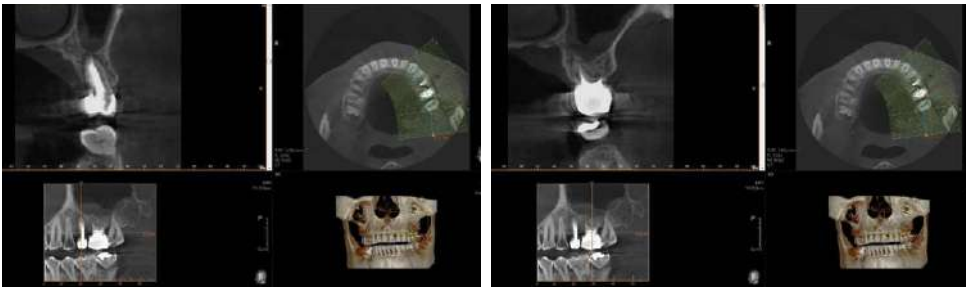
Pre-op CT. #25 (right), #26 (left)
